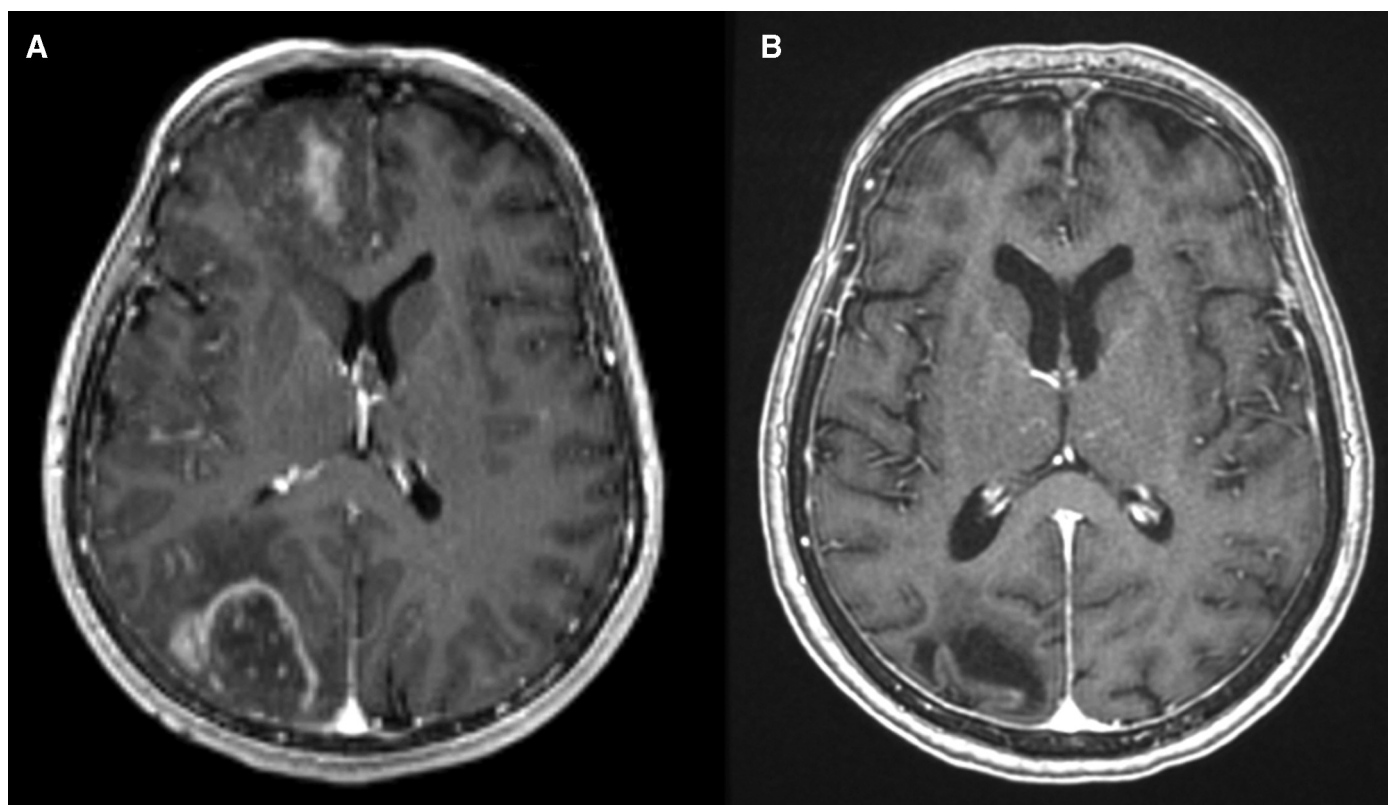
Cerebral magnetic resonance imaging: (A) multifocal ring-enhancing lesions; (B) image enhancement fading within 3 months of oral steroid therapy.
